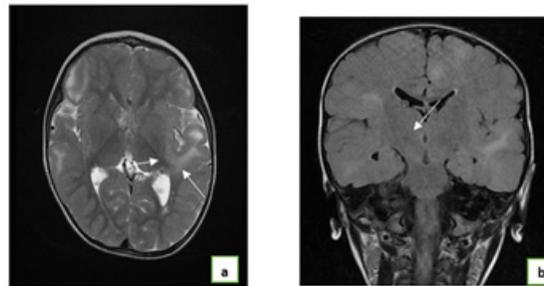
Brain MRI in Axial Cut T2 (a),coronal FLAIR(b):nodular formations under ependymals protruding into ventricular light, T2(a),enhances after injection (associated with ne T2 (cortical signal abnormalities in ranges, triangular in hypersignal T2 and FLAIR(b),not enhanced after gadolinium injection, in relation to cortical tubers.
